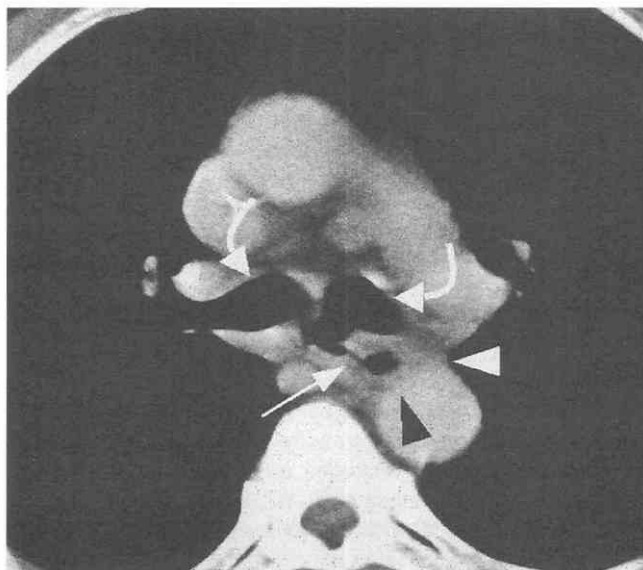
Tracheoesophageal fistula. CT scan shows an air-filled communication (arrow) between the esophagus (arrowhead) and the mainstem bronchus (curved arrows).
